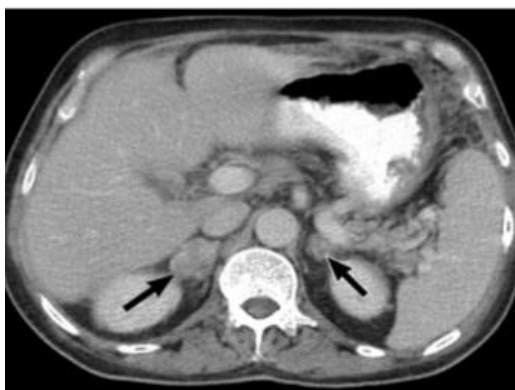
Contrast enhanced CT revealed bilateral hypo attenuated adrenal glands with peripheral rim enhancement
